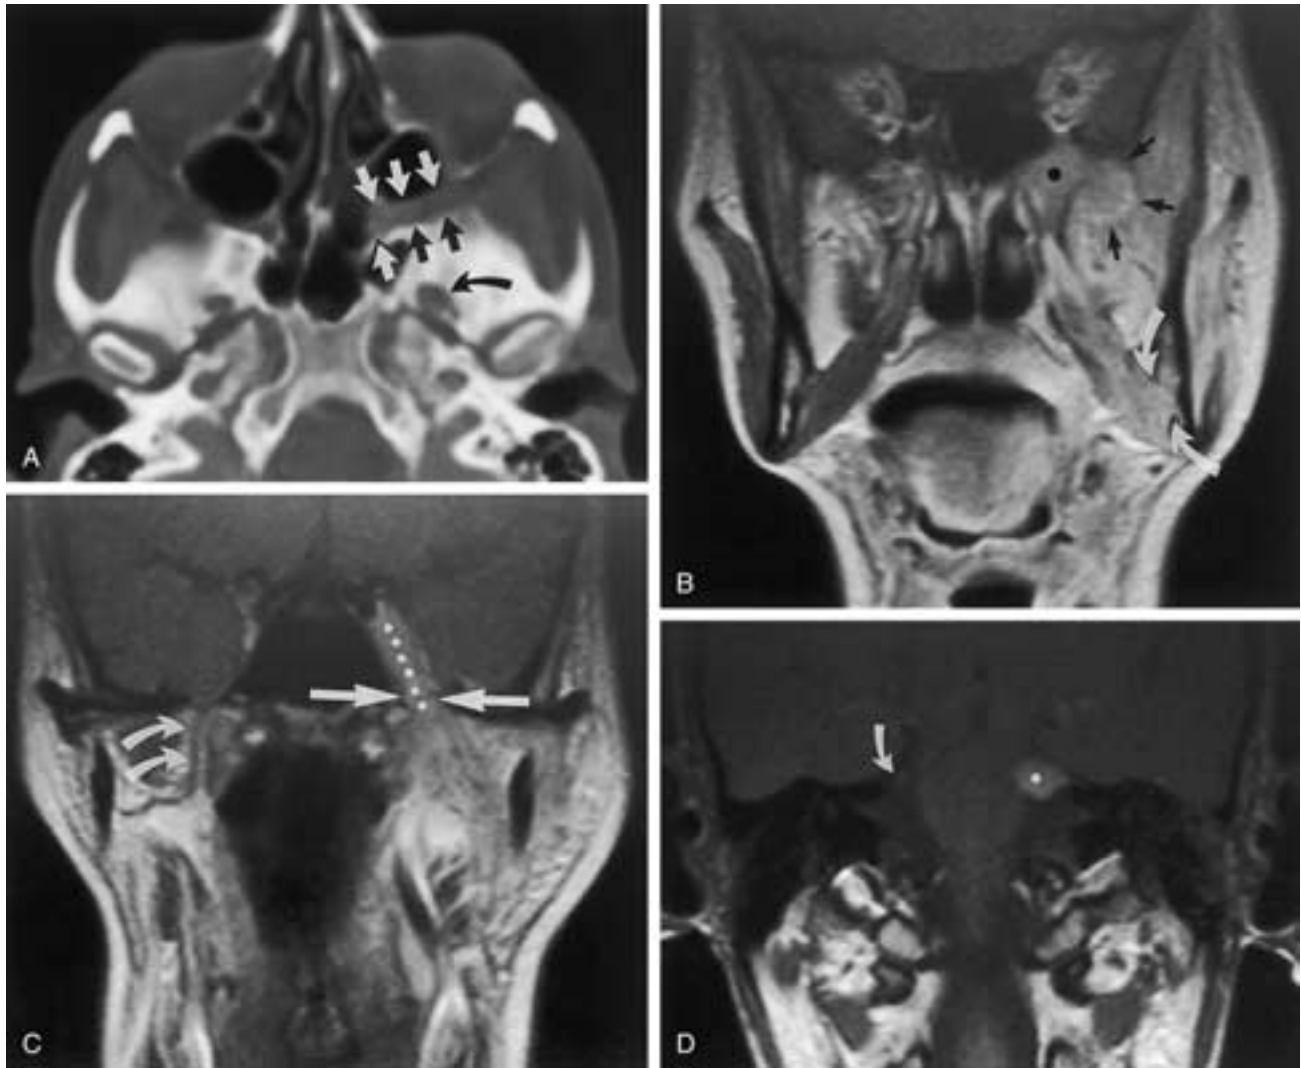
Left retromolar trigone squamous cell carcinoma, now with new left trismus and decreased sensation in the V2 distribution. A, Bone window axial CT scan reveals enlargement of the left foramen ovale (*curved arrow*) and widening of the left pterygopalatine fossa (*straight arrows*). B, Coronal T1-weighted MR image with contrast enhancement demonstrates tumor in the pterygoid fossa (*dot*) and lateral extension into the fat between the lateral pterygoid plate and the medial margin of the infiltrated and enhancing temporalis muscle (*straight arrows*). Also note the infiltration of the medial pterygoid and masseter muscles on the left, identified by their slight enlargement and enhancement. Tumor has also gained access to the mandibular marrow cavity by extension along the inferior alveolar nerve, widening the entrance to the canal on the medial border of the mandible (*curved arrows*). C and D, Coronal T1-weighted MR images following contrast administration. Perineural tumor extension along the left mandibular nerve (V3), widening the left foramen ovale (*arrows* in C) and extending into the cavernous sinus (*dots* in C) is identified. The normal, nonenhancing right mandibular nerve (V3) is indicated by the curved arrows in C. Extension of tumor all the way back to the brainstem is present, identified by marked enlargement and enhancement of the trigeminal nerve at its root entry zone (*dot* in D). The normal right trigeminal nerve in the peripontine cistern is indicated in D by the arrow.
